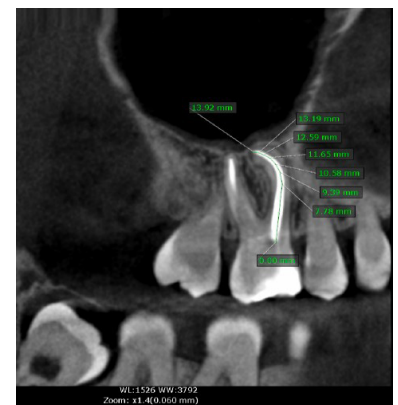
Postop x-ray of the root fillings.
